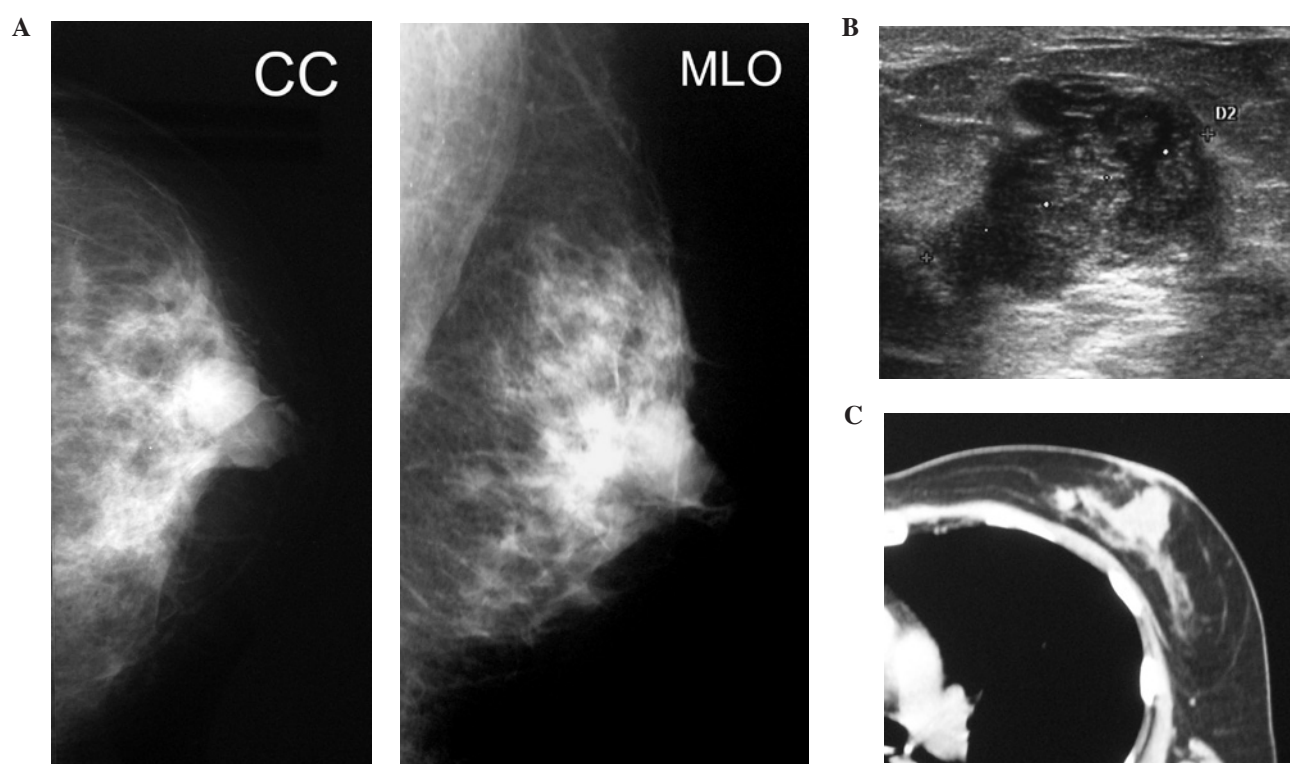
(A) Mammography shows a well-defined lobular tumor mass beneath the nipple. (B) Ultrasonography shows a hypoechoic, heterogeneous, lobular mass with a regular border. (C) A computed tomography scan shows a well-defined mass. CC, craniocaudal view; MLO, mediolateral oblique view.
